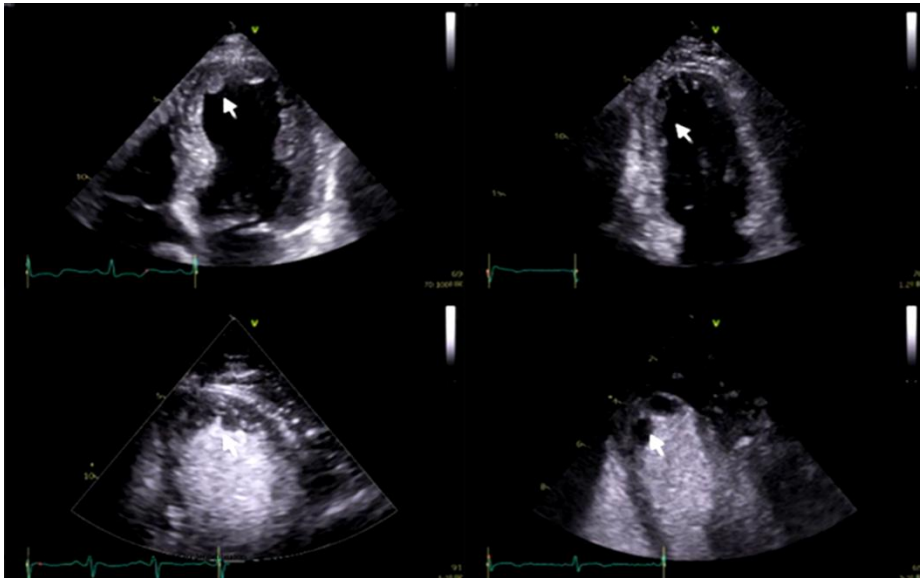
Left ventricular thrombi (arrows) detected by transthoracic echocardiography. Upper panels show non-contrast imaging, while lower panels demonstrate contrast-enhanced visualization.
